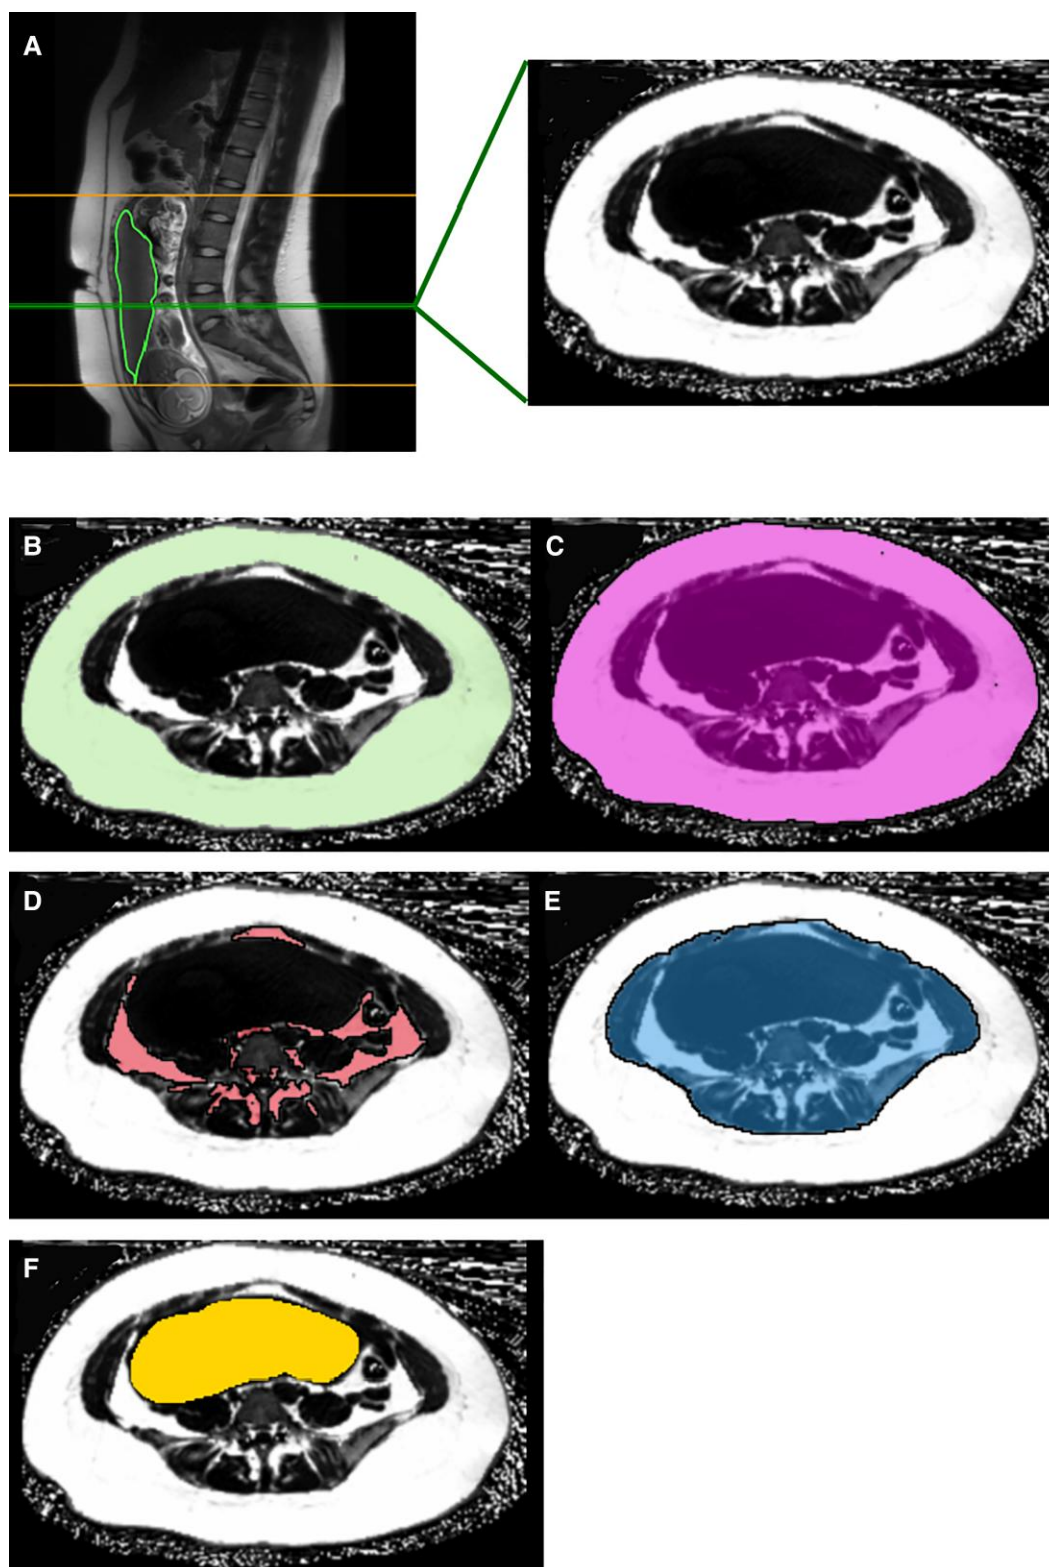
Maternal adiposity analysis. A) a sagittal plane MRI image (top left) of a representative subject showing the corresponding axial plane (top right) at lumbar vertebral level L5 (horizontal green line in the sagittal plane). B) The subcutaneous fat area of image A is highlighted in green. C) The total body area of image A is highlighted in pink. D) The visceral fat area of image A is highlighted in red. E) The total visceral area of image A is highlighted in blue. F) The uterus in image A is highlighted in yellow.
